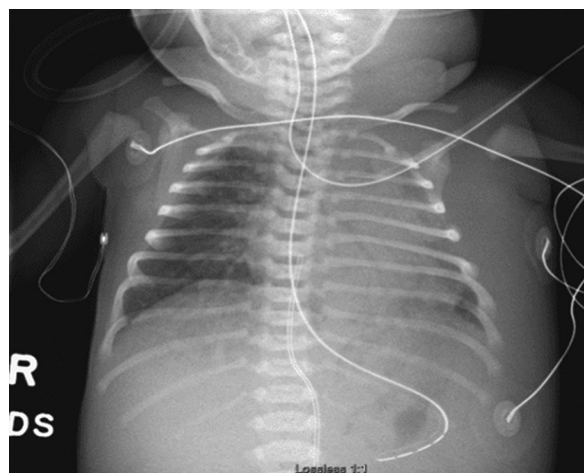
Initial chest X-ray demonstrates the umbilical venous catheter tip terminating above the cavoatrial junction.
